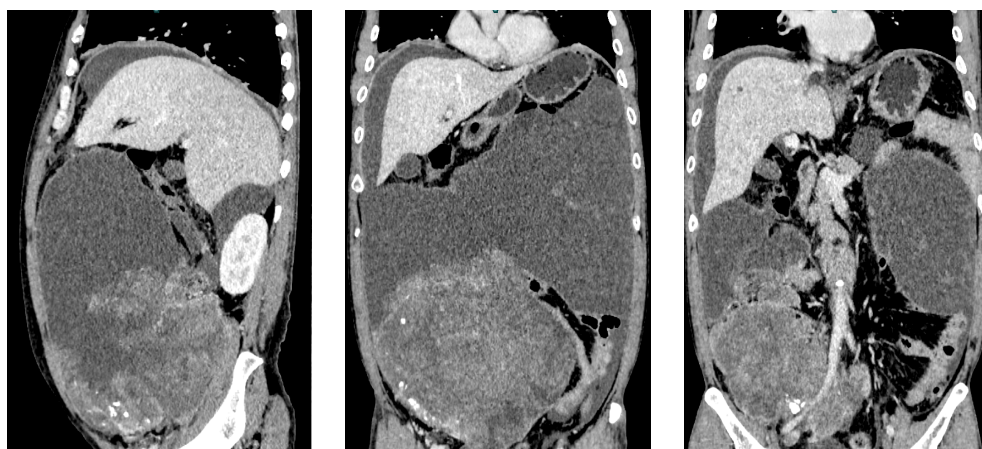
增强 CT 重建图显示混杂密度团块, 上至肝下缘, 下到盆腔, 实性部分动脉期呈现不均匀强化
